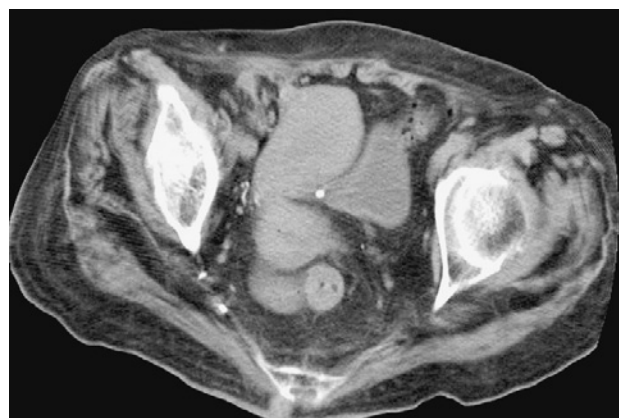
Computed tomography of the abdomen indicated no recurrence of the hernia.
